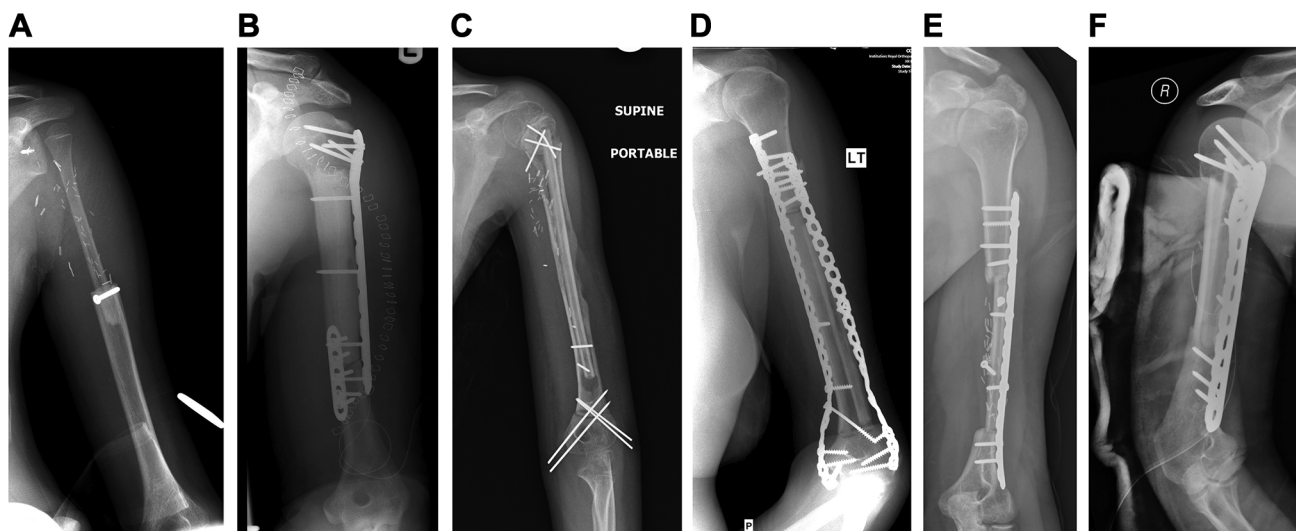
Representative postoperative radiographs. (A) Vascularized fibula epiphyseal transfers, (B) Reimplantation alone, (C) Reimplantation + vascularized fibula, (D) Reimplantation+non-vascularized fibula, (E) Vascularized fibula alone, (F) Vascularized fibula+allograft.
